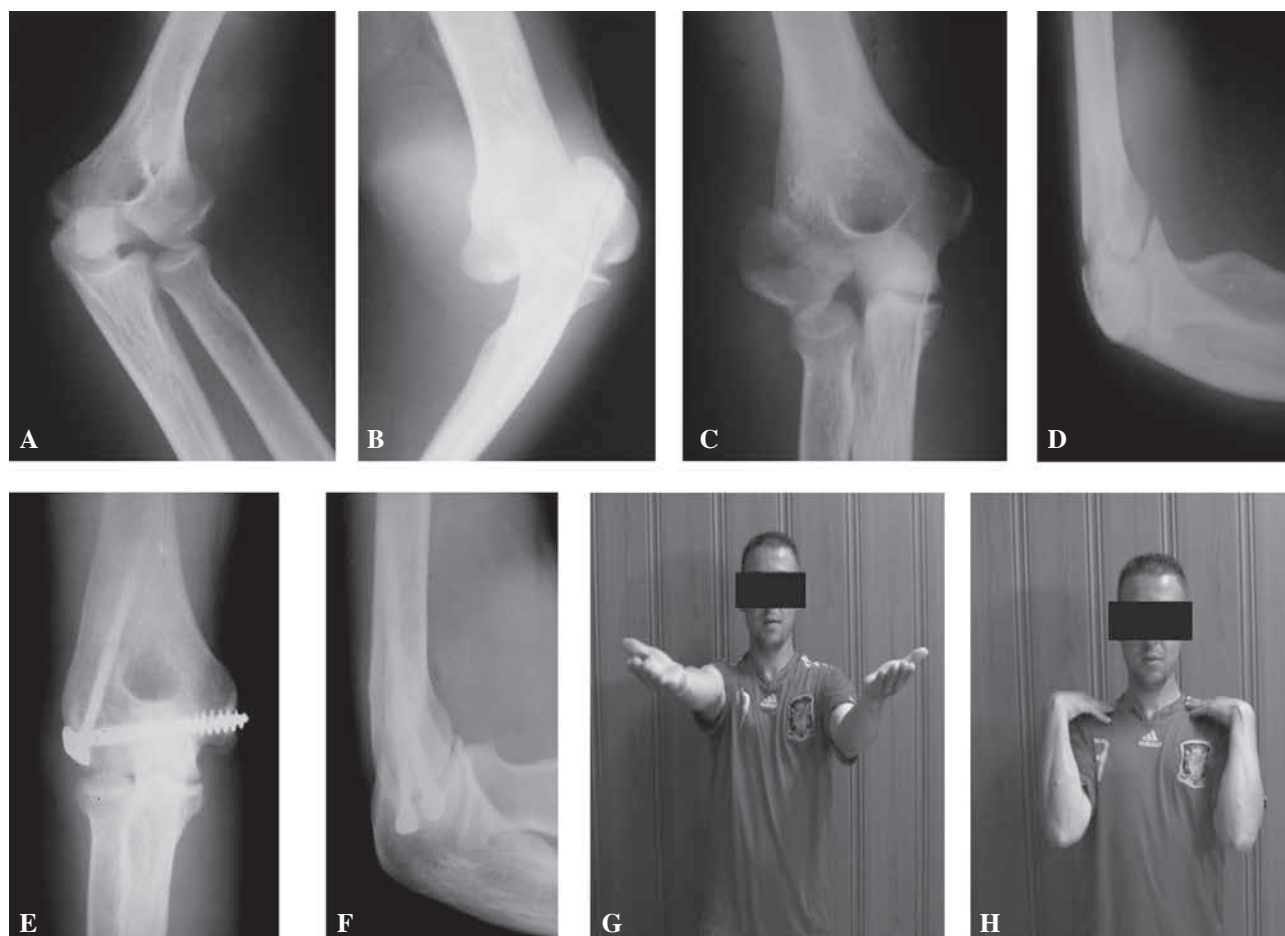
Patient 4. Pre-operative X-rays (A, B), after closed reduction (C, D), showing the elbow fracture-dislocation (AO-Type- B1.2/ posterior elbow dislocation). (E-H). Results at 4.57 year follow-up.
